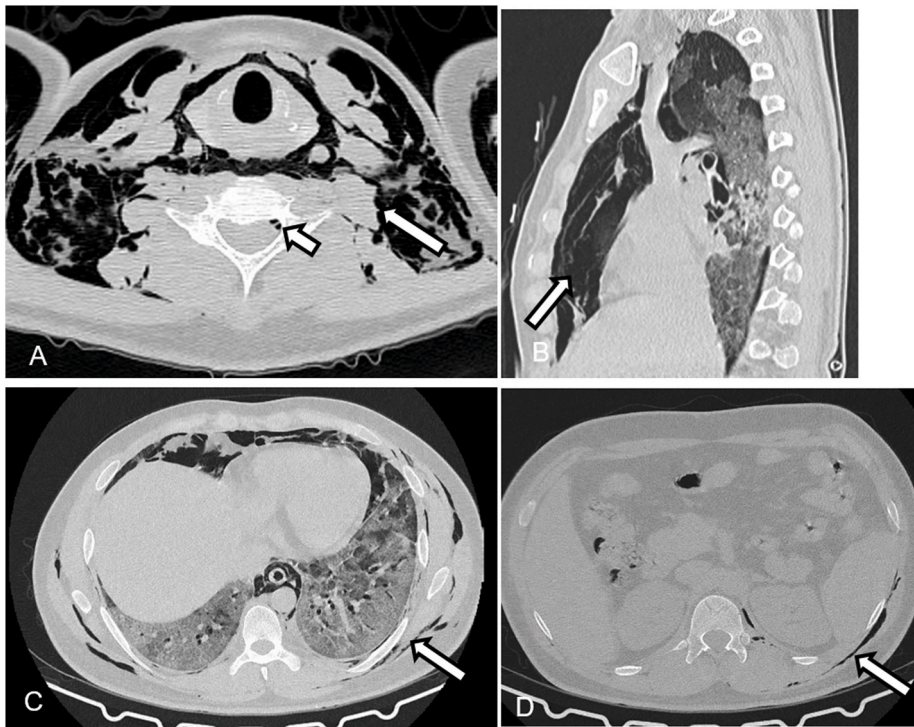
Segmental distribution of subcutaneous and mediastinal emphysema. Axial (A, C, D) and Sagittal reformatted (B) CT images in lung window showing A: Subcutaneous emphysema in the neck region (long arrow) and epidural pneumorrhachis (short arrow), B: Tension pneumomediastinum (marked by white arrow)., C: Subcutaneous emphysema in the chest wall (marked by white arrow), D: Subcutaneous emphysema in the abdominal wall (marked by white arrow).
